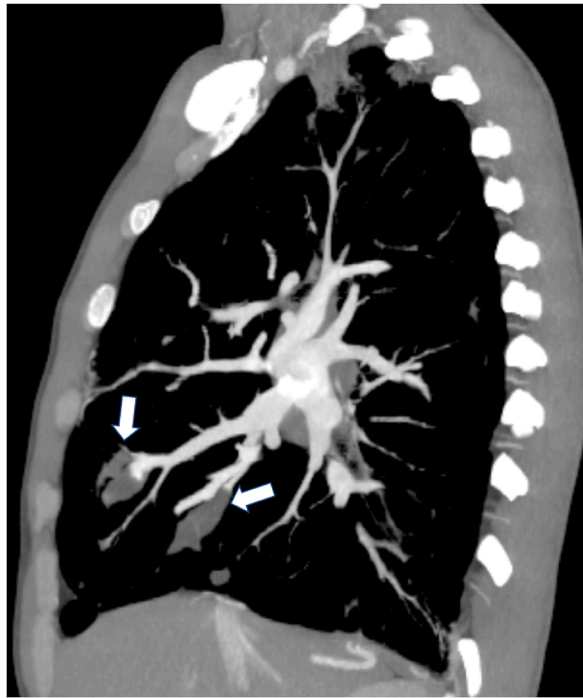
Sagittal post-contrast CT scan MIP image: Intra-arterial defects corresponding to echinococcal cysts extending along the segmental pulmonary arteries of the middle lobe (arrows).
